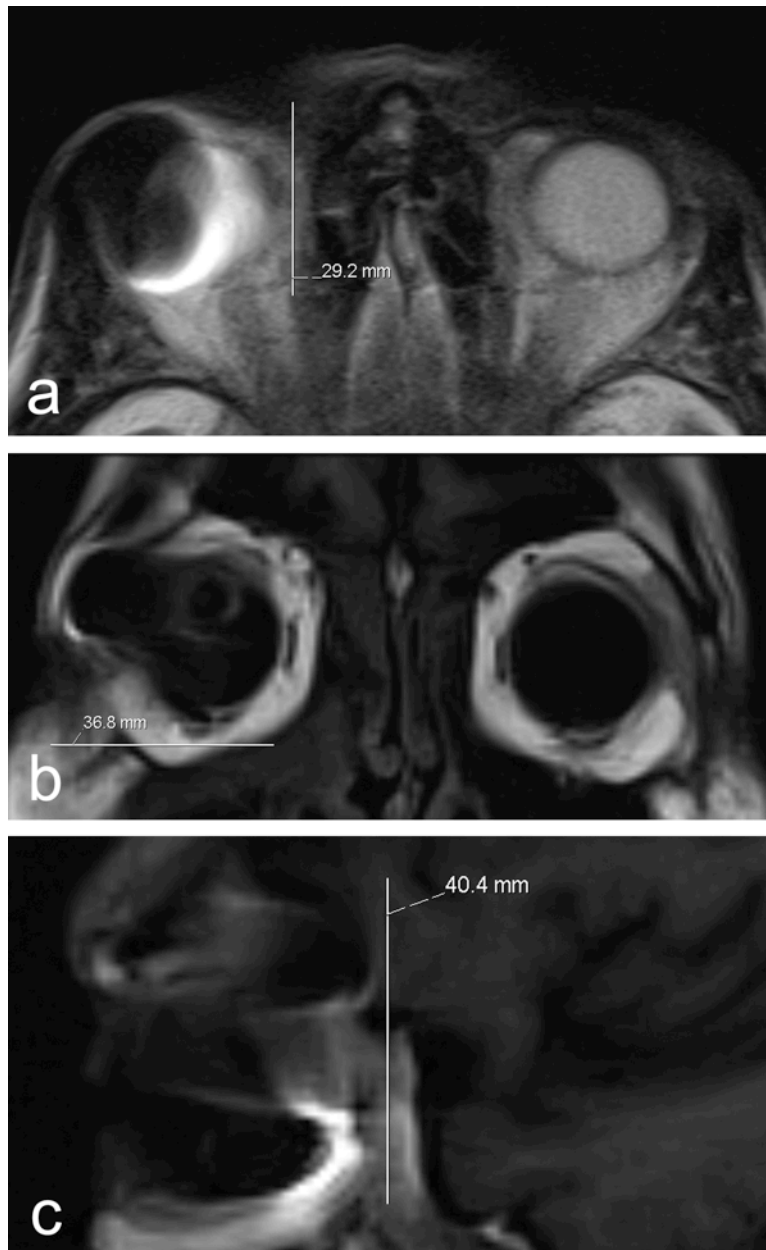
Magnetic Resonance Imaging at 1.5-Tesla with the Argus® II retinal implants in the right eye of a patient, on a) axial T2-weighted, b) coronal T1-weighted and c) sagittal T1-weighted acquisitions. The measurements are the maximal dimensions of the artifact (in millimeters) in the anterior-posterior (AP), transverse (TR) and superior-inferior (SI) planes. (Image from (Luo et al., 2013))
